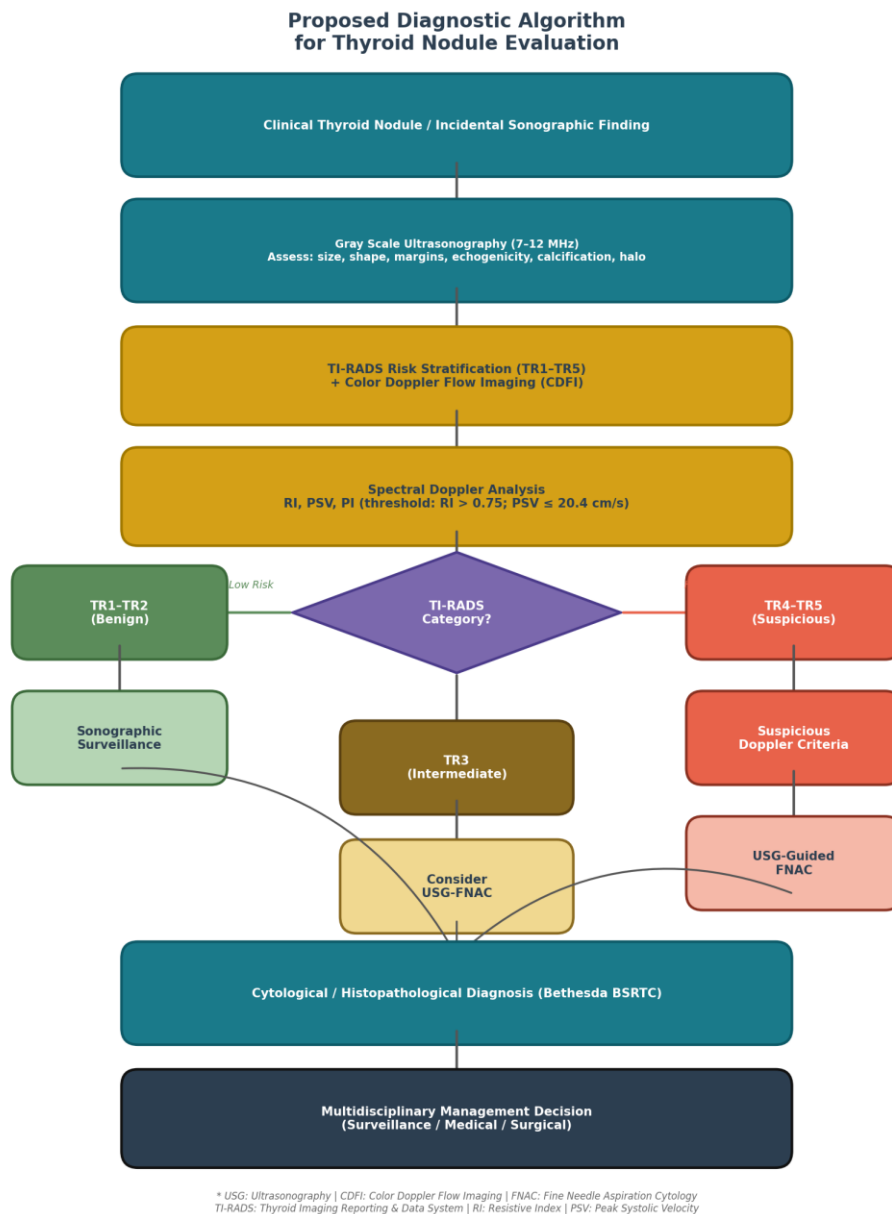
Proposed diagnostic algorithm for thyroid nodule evaluation integrating gray scale USG, TI-RADS stratification, CDFI, and spectral Doppler findings.
